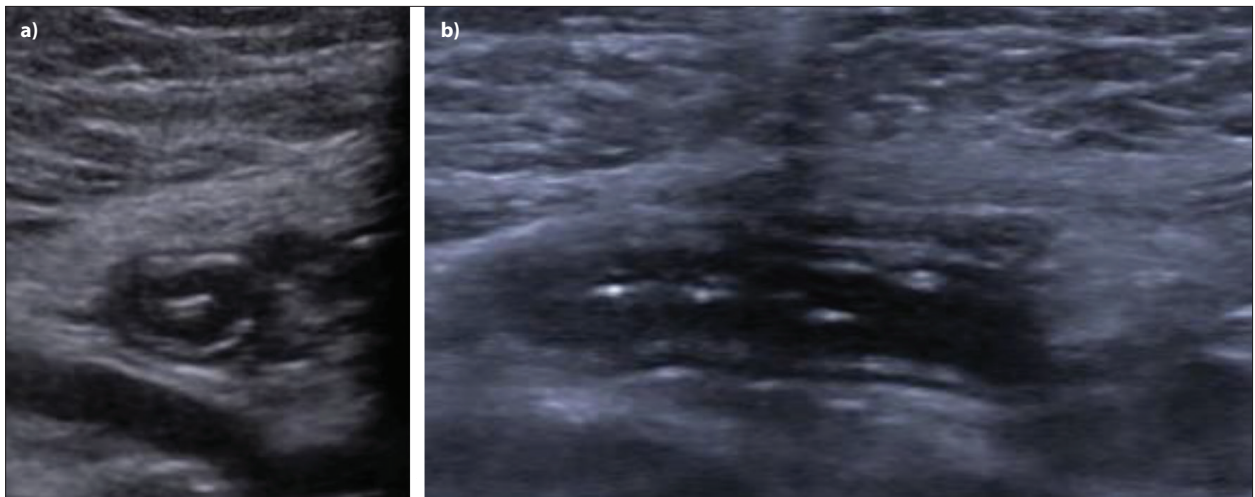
Acute uncomplicated appendicitis in a seven-year-old boy with a one-day history of abdominal pain, vomiting, and diarrhea; axial (a) and longitudinal (b) grayscale ultrasonography images of the right lower quadrant shows noncompressible 8 mm appendix with wall thickening and typical target sign
